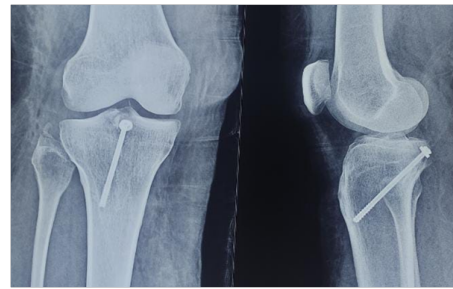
X-ray at final follow-up
